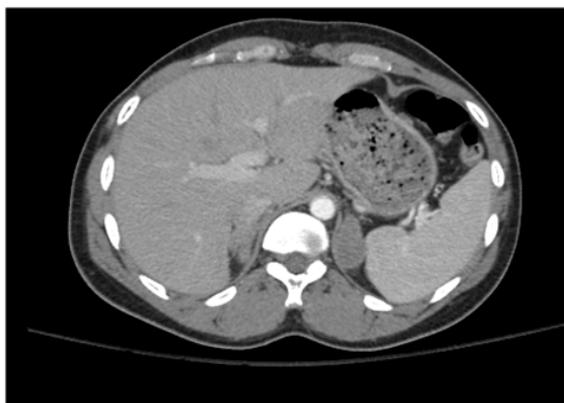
CT scan of the abdomen showing a 5.8 cm mildly enhancing mass in the left adrenal gland.
